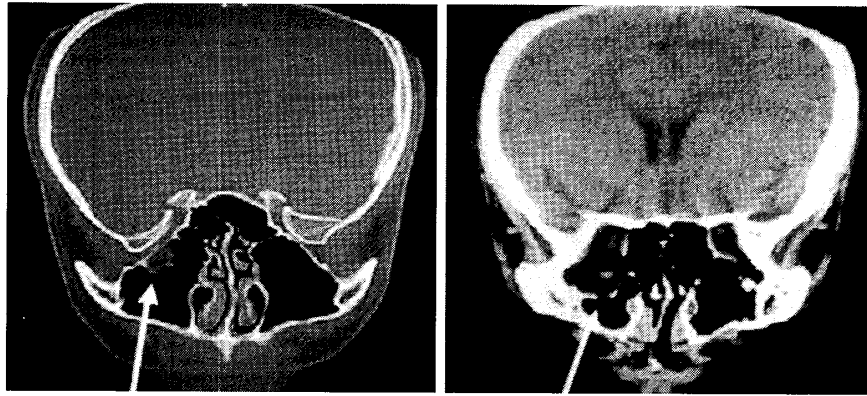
Computed tomography (January 5, 1998)
